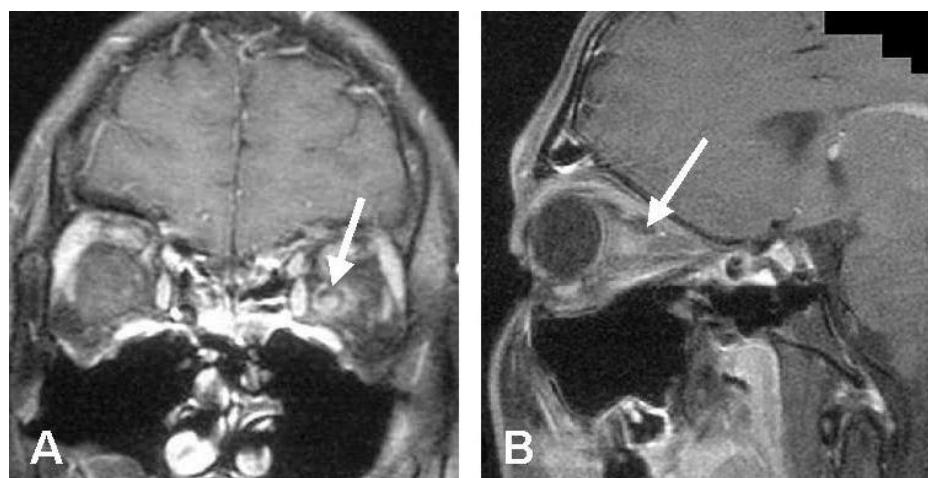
MRI of the brain: increased signal from the affected optic nerve.
